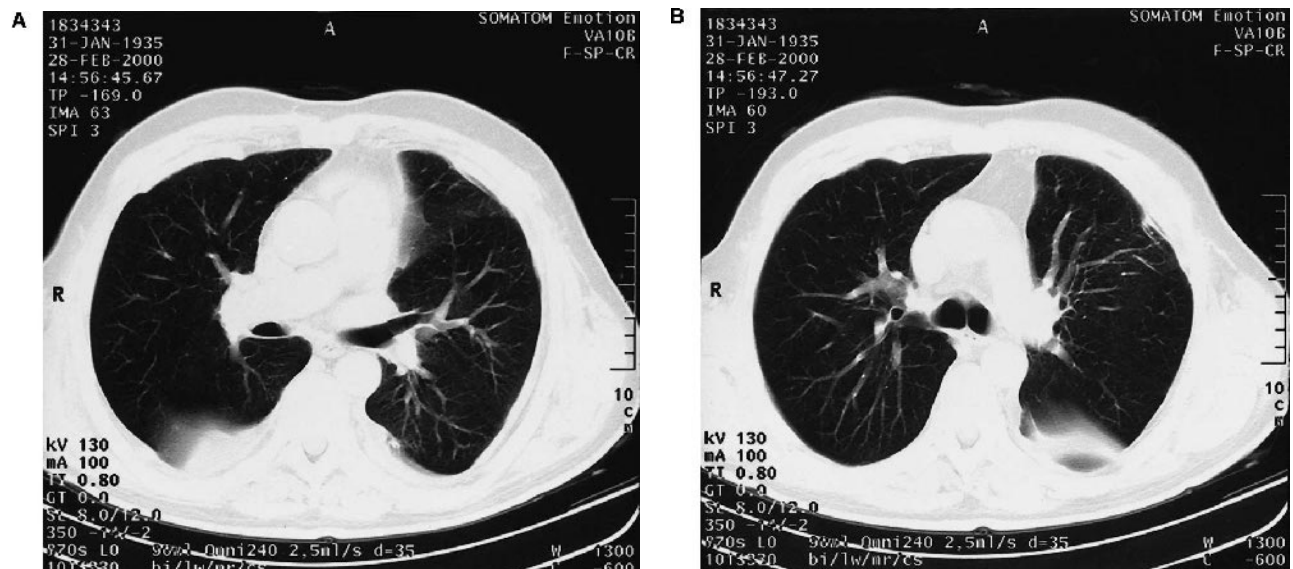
(A and B) CT scans of Patient 3. Bilateral pleural thickening on several levels.
